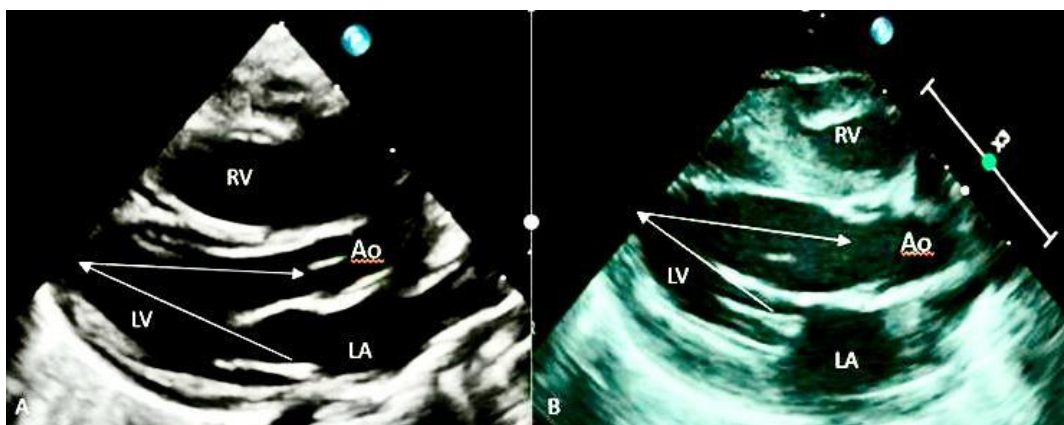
2D echocardiogram parasternal long axis view: A. In normal cardiac anatomy, distance from the mitral valve to left ventricular (LV) apex and from LV apex to aortic valve is same. B. In AVSD, LVOT is elongated and distance from LV apex to left AV valve annulus is shorter. LA, left atrium; RV, right ventricle; Ao, aorta.
